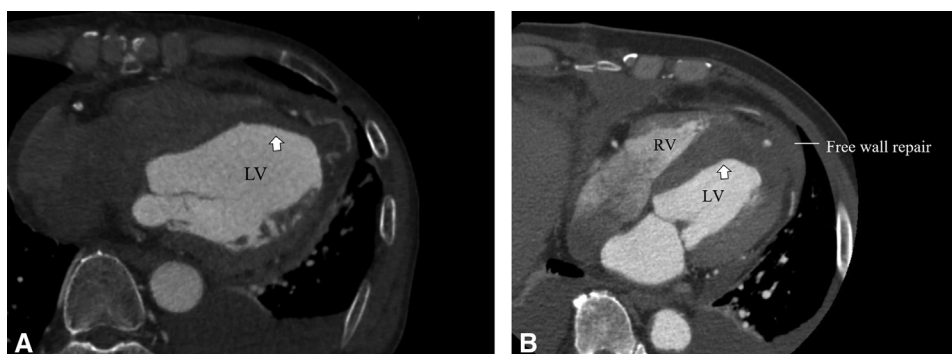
Postoperative computed tomography showing repaired ventricular septum by 2 separate patches with BioGlue (arrow) for anterior VSR (A) and anterior VSR and free-wall repair (B) without a residual shunt. VSR, Ventricular septal rupture; LV, left ventricle; RV, right ventricle.
